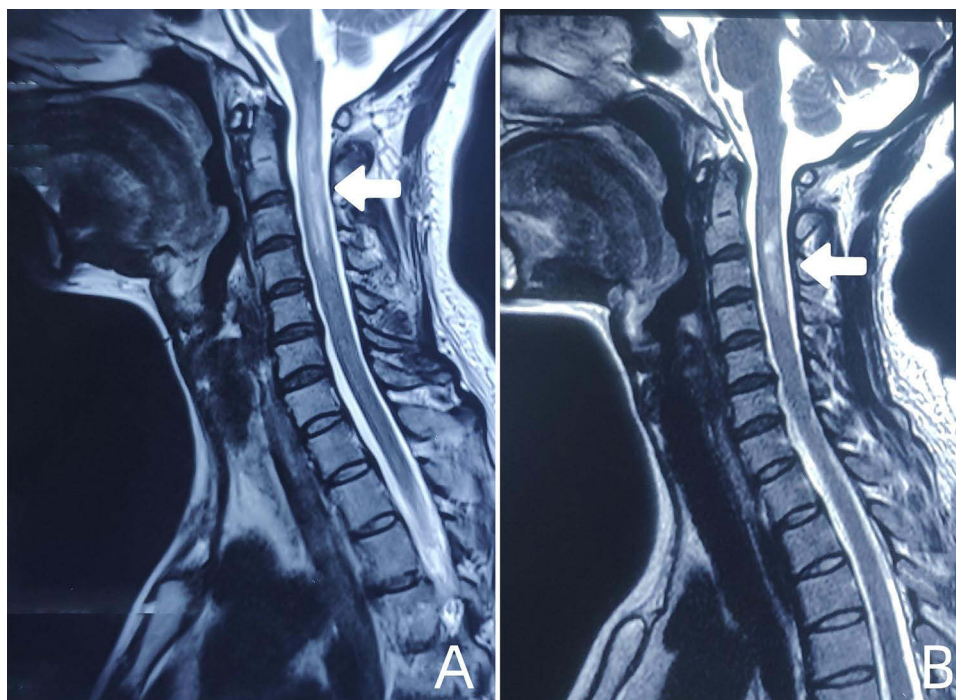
Initial and relapse MRI enhancement images of the patient. (A) Initial episode: long segmental abnormal signal in the cervical cord (arrow), striated long T1 signal seen from the medulla oblongata to the C7 vertebral level. (B) Relapse: abnormal signal (arrow) of the spinal cord is seen at the level of C2-4.
